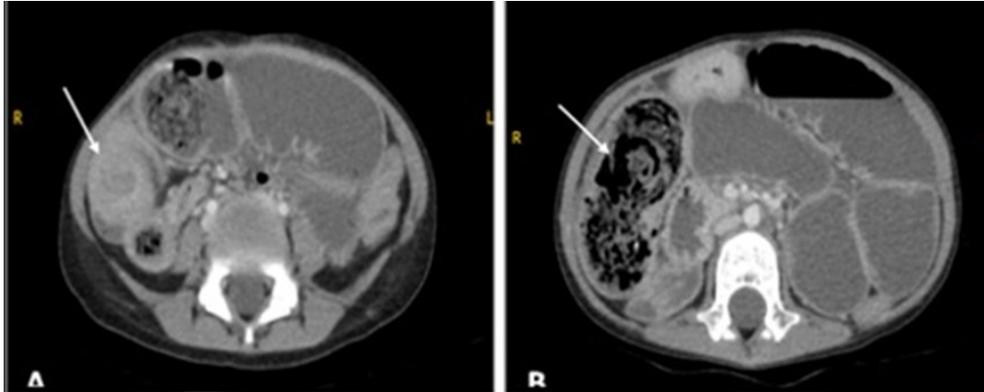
Computed tomography of the abdomen with contrast. *A: Axial image showing dilated bowel loops and whirlpool sign (arrow) indicating the presence of intussusception. B: Axial image showing dilated bowel loops and fecaloma (arrow).*
